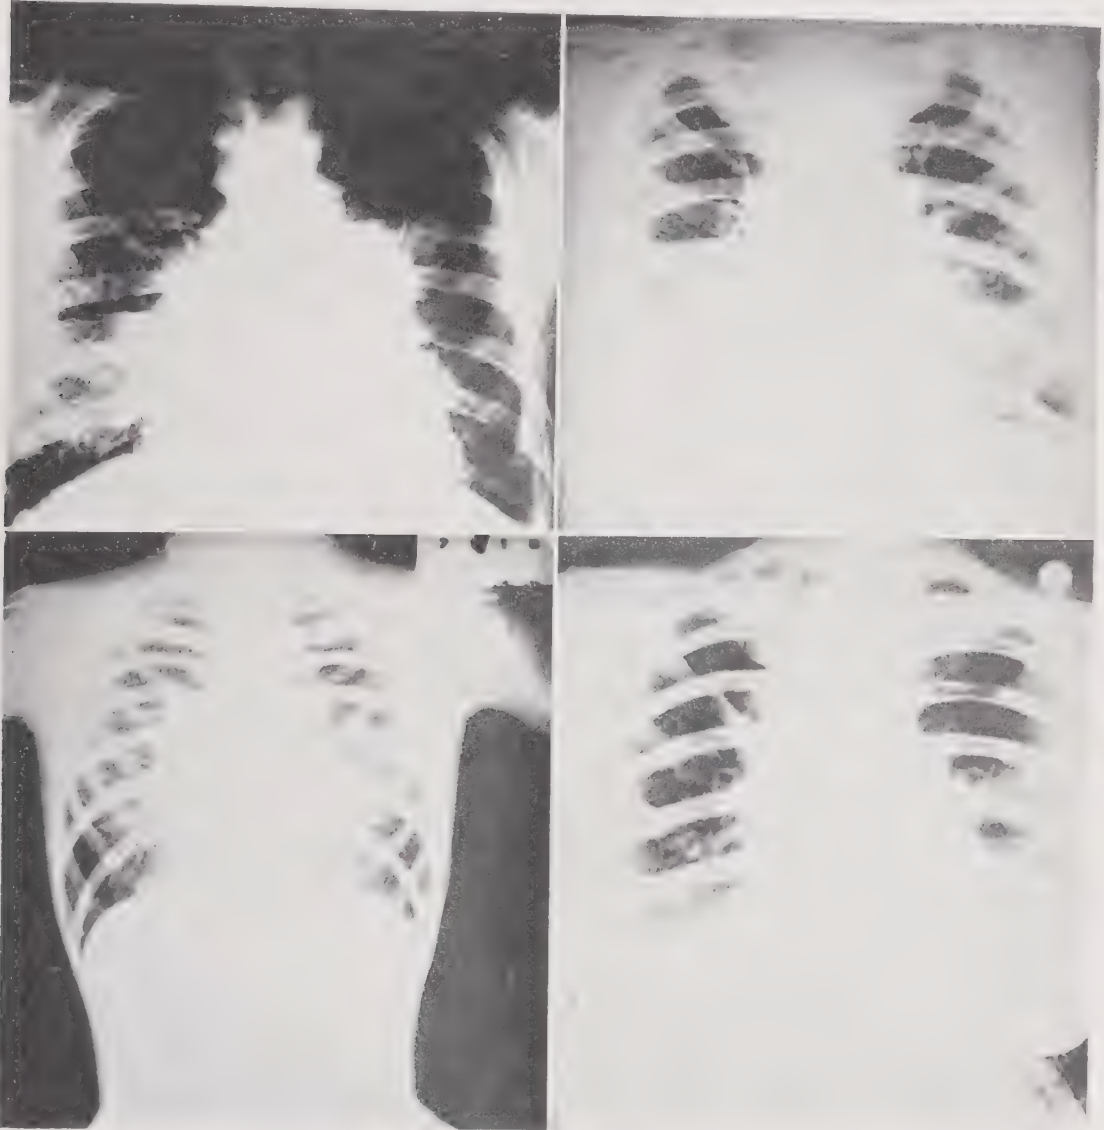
Importance of routine roentgen examination. All that wheezes in the allergist's reception room is not asthma. Upper left: malignancy. Upper right: dyspnea due to diminished air space (fluid). Lower left: child with an obscure metabolic disturbance involving deposition of calcium throughout the lung. Condition was progressive, not relieved by parathyroid therapy. Lower right: true asthma with associated advanced pulmonary tuberculosis and cavities, seen between sixth and seventh ribs. One should know whether one is dealing with true asthma and whether other pathology requires simultaneous treatment.
